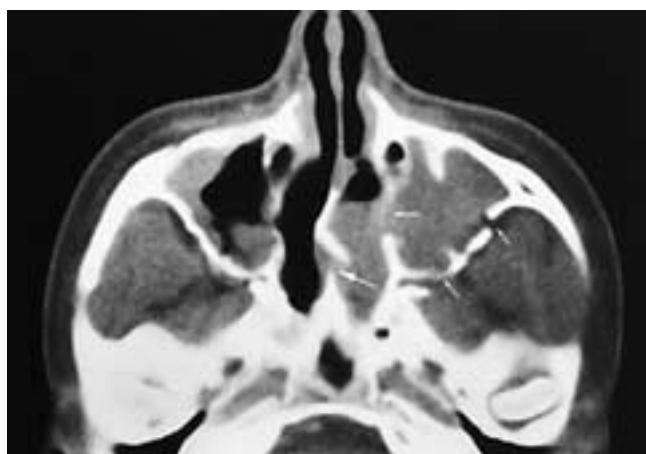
Axial CT scan shows fractures of the left maxillary sinus's posterolateral and medial walls (*small arrows*) and a fracture of the nasal septum (*large arrow*).
